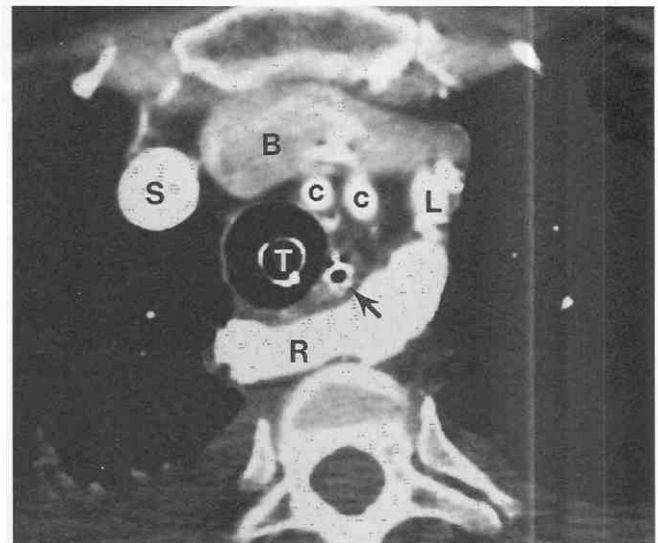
Aberrant right subclavian artery. Contrast-enhanced CT shows enhancement of retrotracheal right subclavian artery (R). A nasogastric tube can be seen in the esophagus (arrow). B, brachiocephalic vein; c, left and right common carotid arteries; L, left subclavian artery; S, superior vena cava; T, trachea with endotracheal tube.
